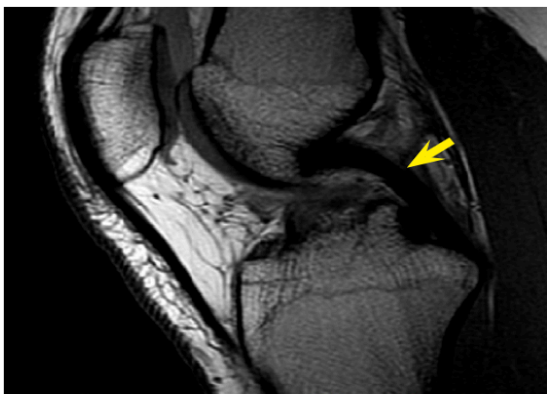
Sagittal PD MRI demonstrating a normal PCL
